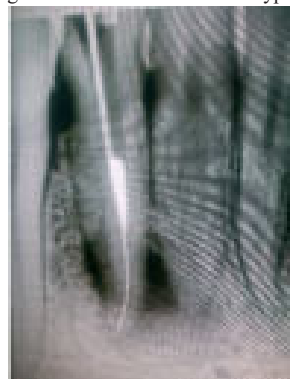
Radiograph showing #15 K-file bypassing the sewing needle fragment in 41. Then the canal was instrumented using ISO # 25 and # 30 K-file. Then braiding technique was done using two # 15 K-file and one # 20 K-file [Figure 3]
